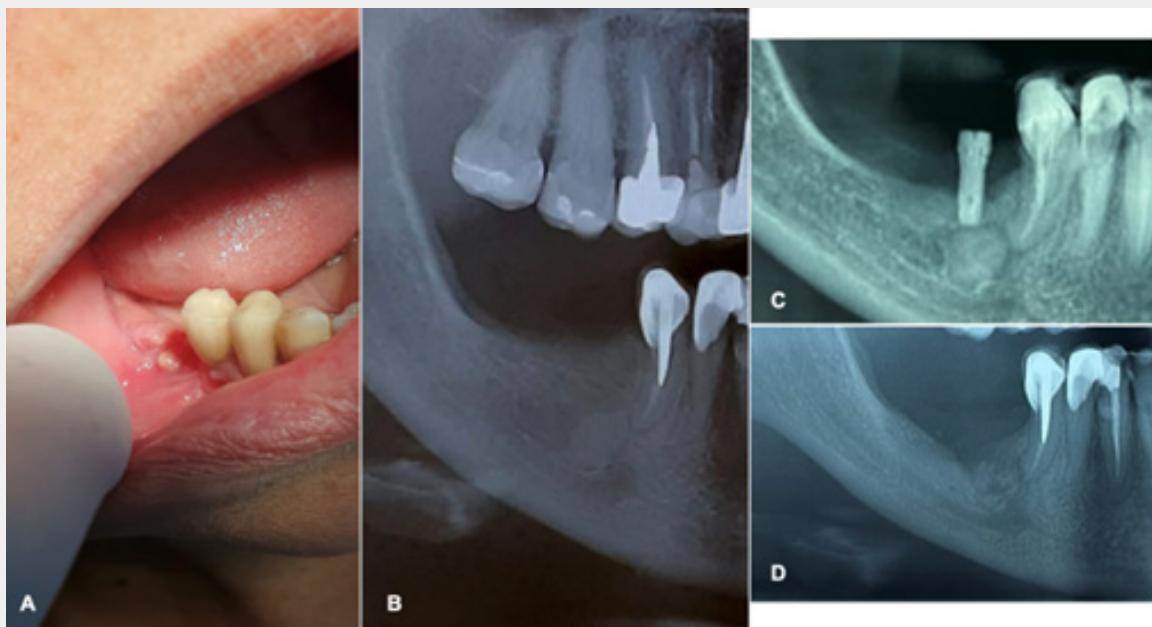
Infected focal COD following dental implant placement. A, Intraoperative fistula located in the lower right first molar region. B, Initial panoramic radiograph showing a well-defined radiopaque lesion in the molar region. C, CBCT panoramic reconstruction showing DI placement within the lesion area. D, Postoperative radiographic exam demonstrating bone healing and absence of infection after the removal of both lesion and DI.
